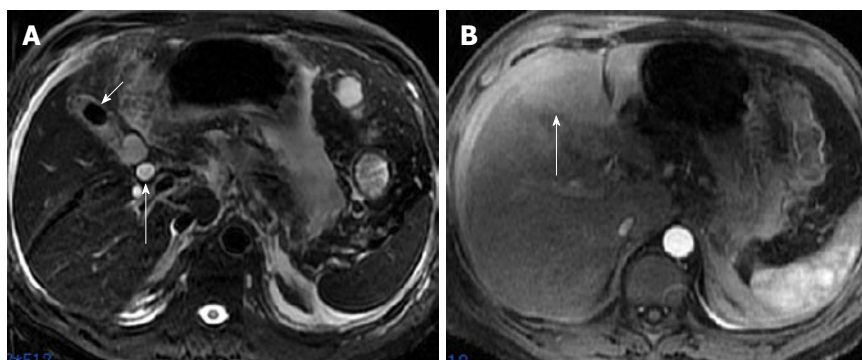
A 49-year-old man with acute pancreatitis combined with cholecystitis, gallbladder stone and common bile duct dilatation. Respiratory-triggered axial fast recovery fast spin-echo T2-weighted image (A) shows cholecystitis and gallbladder stones (short arrow) as well as common bile duct dilatation (long arrow). Patch- or wedge-shaped hepatic abnormal perfusion is found in the left lobe of the liver on arterial phase images (B, arrow).
